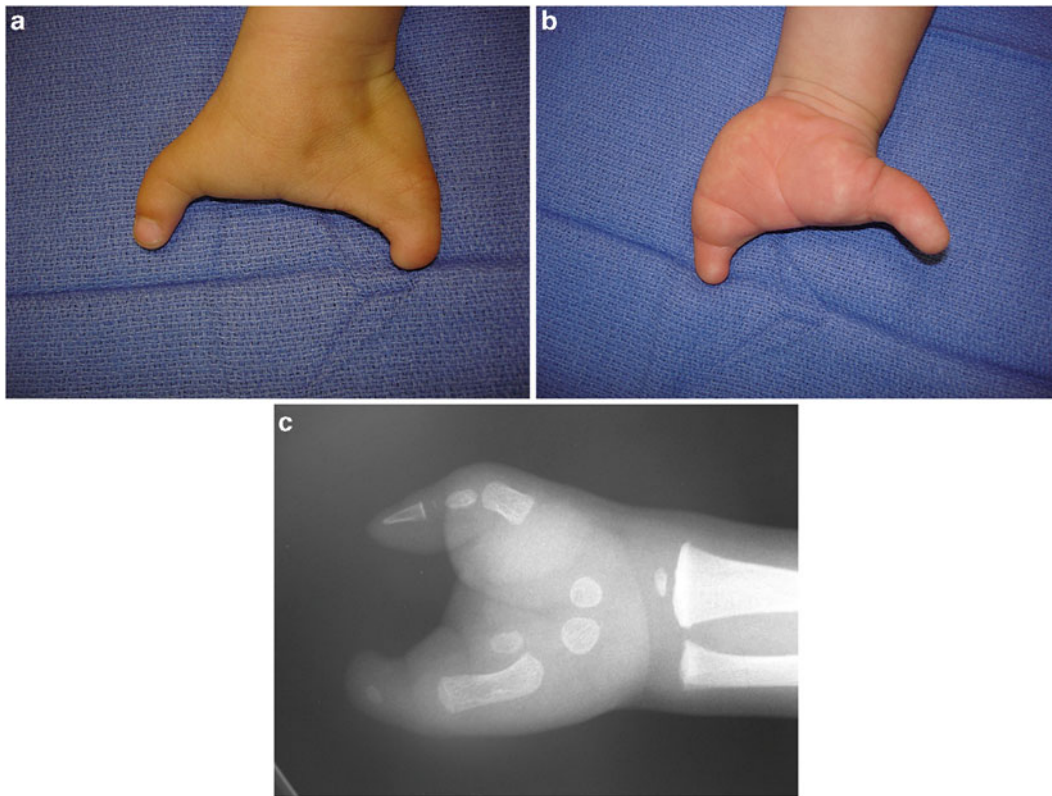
(a–c) Dorsal and palmar photographs and radiograph of an “atypical” cleft hand, now classified as a central absence or oligodactylic type II symbrachydactyly, affecting the left hand of a 4-year-old boy. Published with kind permission of Neil F. Jones ©2014. All rights reserved
